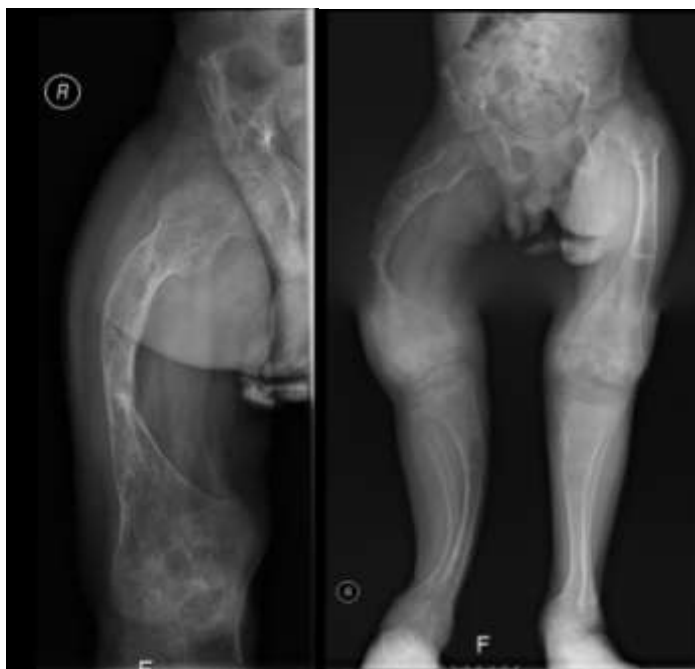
A, B. Full-limb film X-ray showed a cystic lesion in the right femur.
